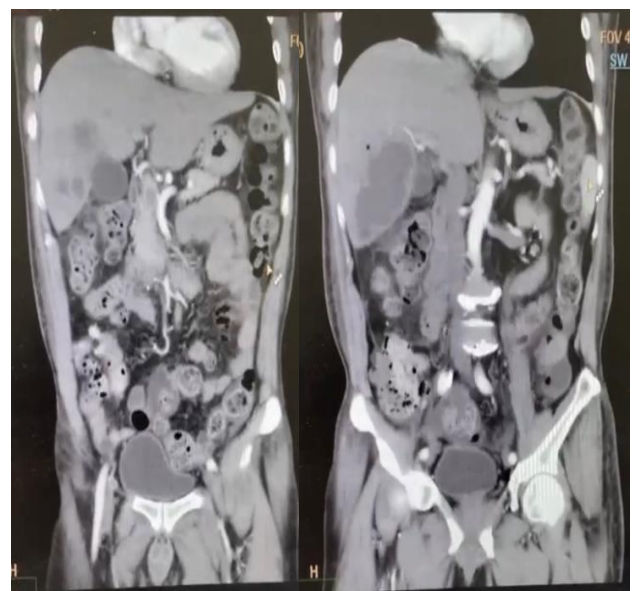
Abdominal computed tomography with contrast revealed liver enlargement with size 15 cm, multiple cystic lesions in segment 5, 6, 7, and 8 right lobes of the liver with the largest size of lesion is 6.4x7.1x8.9 cm.
